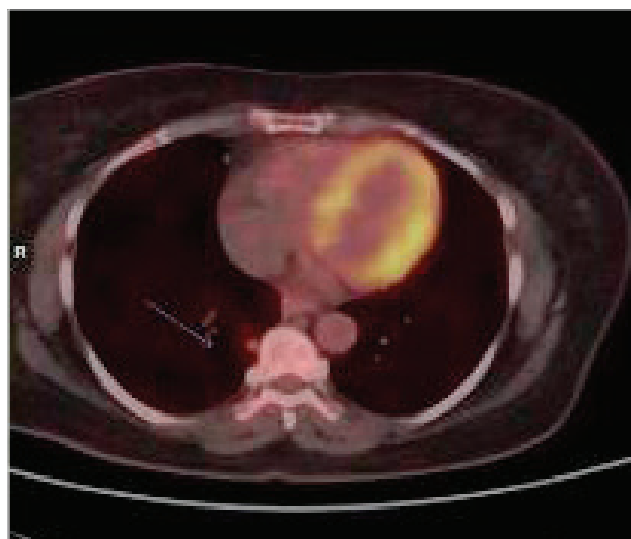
(Case 2) PET CT at follow up: Transaxial view of lung showing metabolically active lesion(0.7cm x 0.7cm) in right lower lobe lung.
